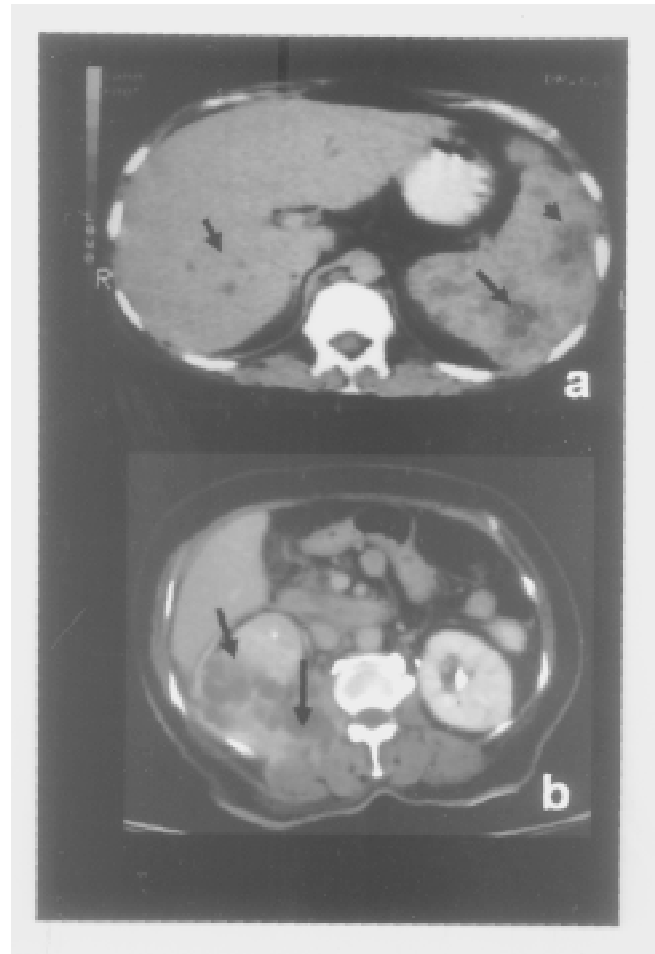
Contrast enhanced CT scan of the abdomen showing multiple hypointense areas in the liver and spleen (arrows) (a), hypodense lesions in the right kidney (arrow) with extension into the poas and paraspinal muscles (arrow) (b) CT guided fine needle aspiration confirmed the diagnosis of tuberculosis.
